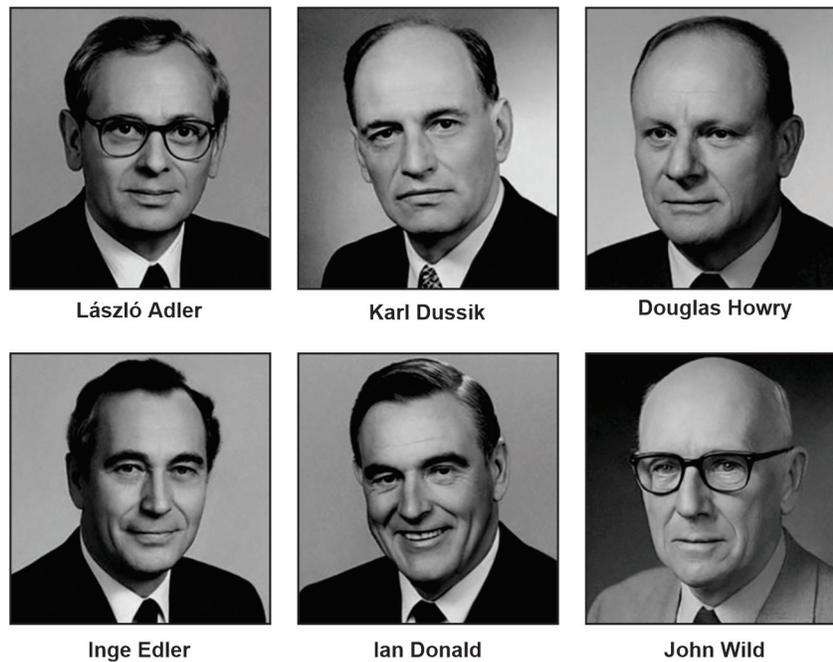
Contributors of ultrasound
